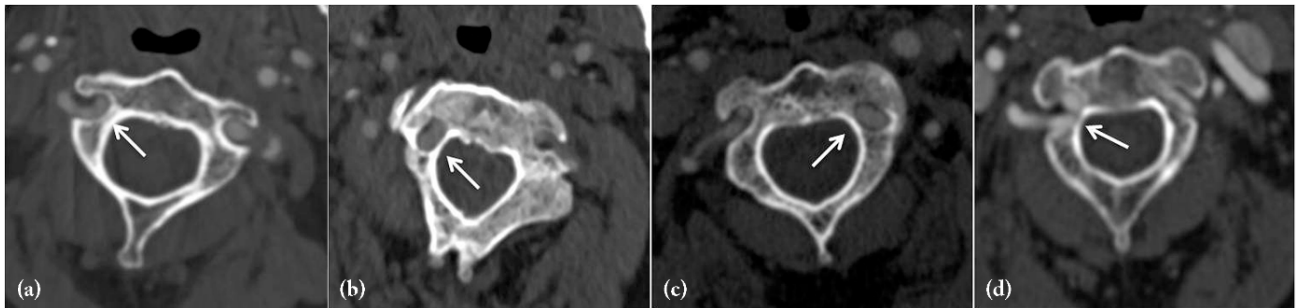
CT-angiography axial MPR images through the C2 intraosseous canal of four different patients demonstrate variable degrees of narrowing of pedicles indicating medial-shifting VA for each four cases (arrows)
